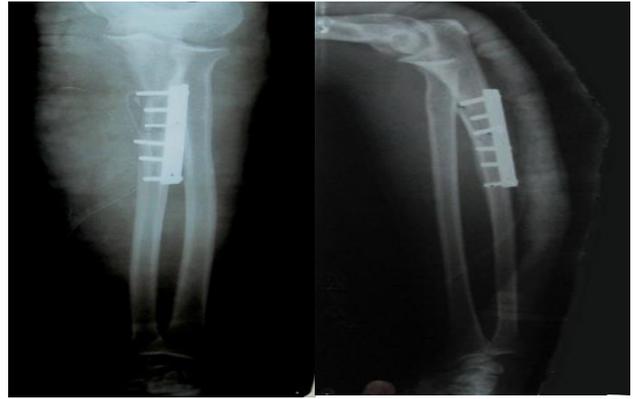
Post-operative 6 weeks X-rays.
